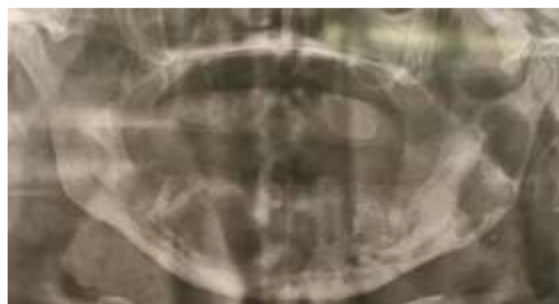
Radiographic view at the end of the surgical procedure
